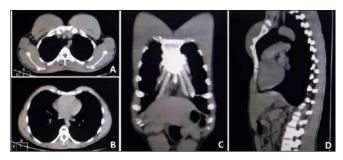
CT examination. A. Section view showing thickened sternal angle; B. Section view showing the sternal body; C. Coronal view showing diseased sternum; D. Sagittal view showing diseased sternal angle and sternal body
